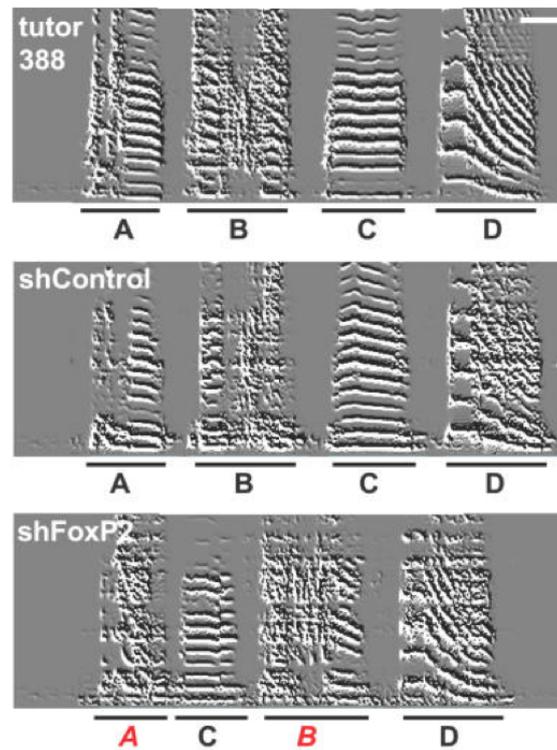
Representative sonograms from control and FOXP2 knock-down birds that had the same tutor. Both the order of individual elements and the imitation of the elements themselves (red italics) was affected (modified from Haesler et al., 2007, Fig. 3).
